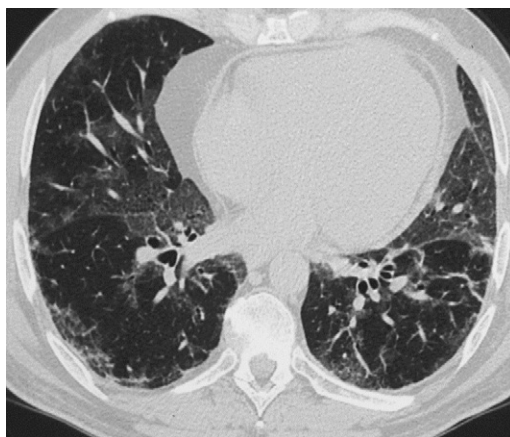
HRCT of a patient with chronic hypersensitivity pneumonitis.
